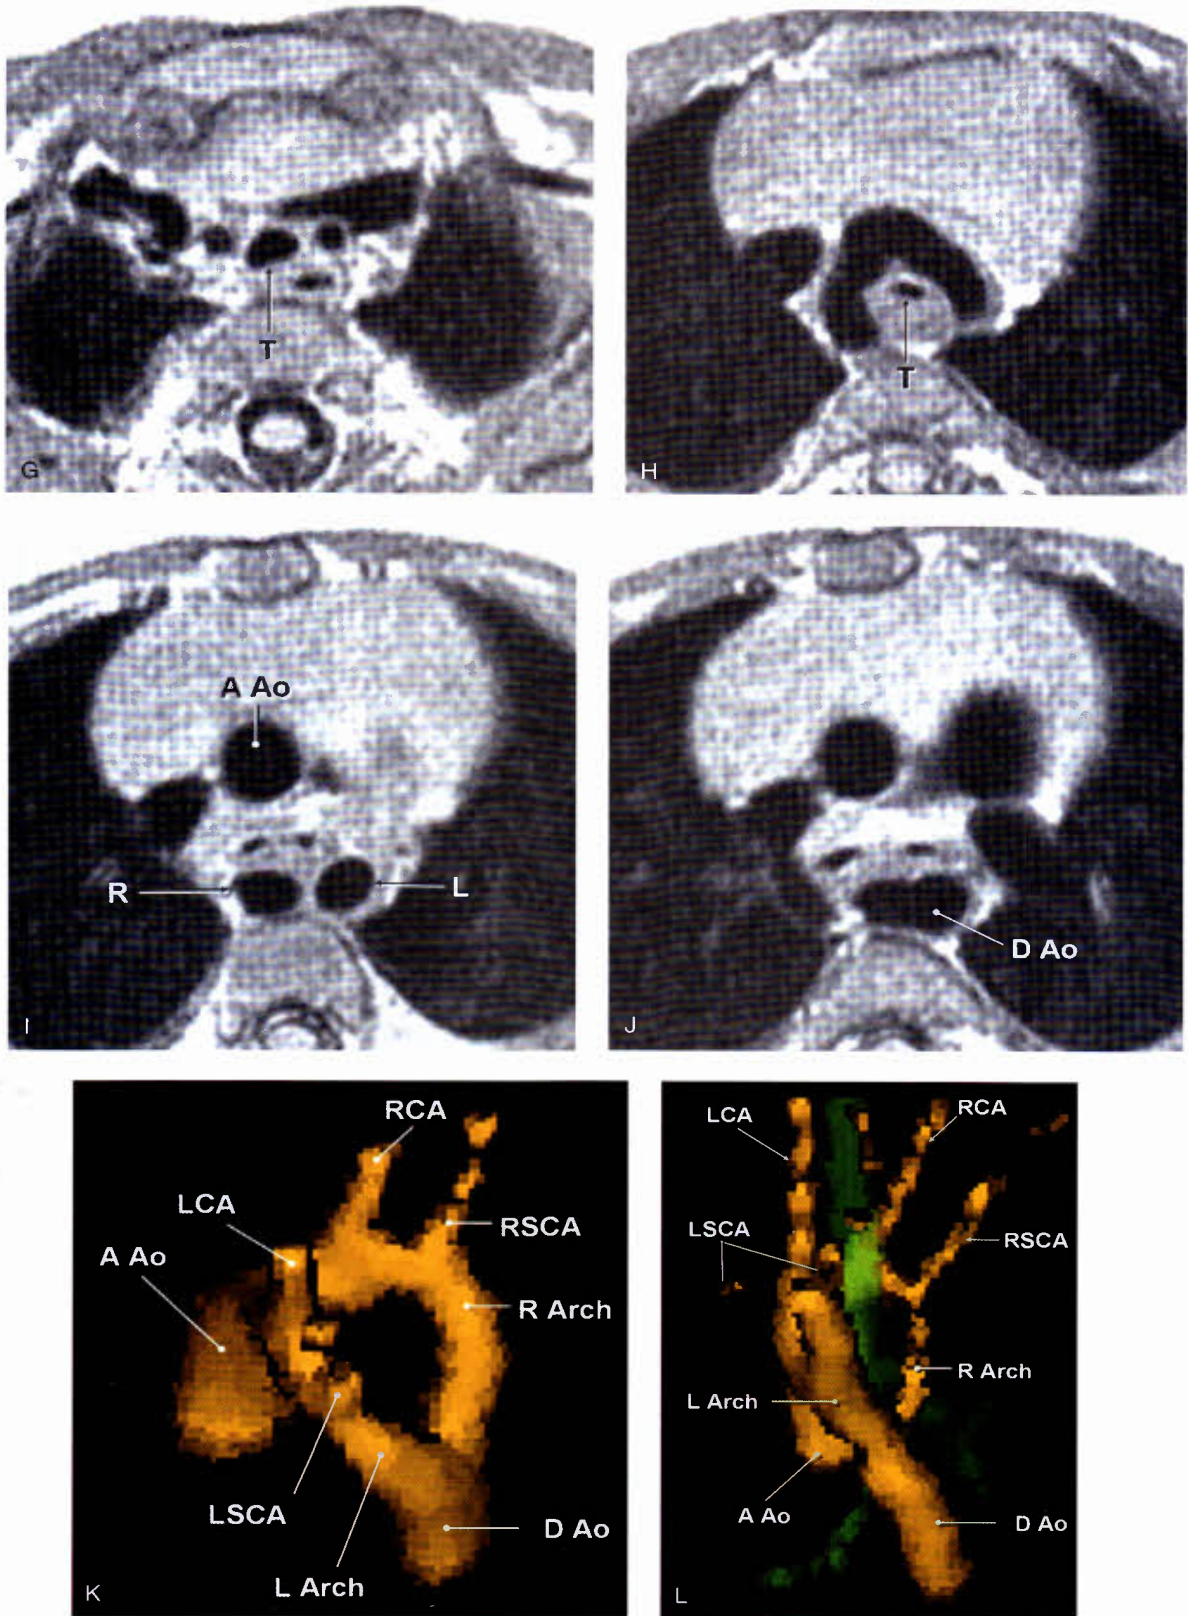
(Continued) G–J: transverse cuts, cranial to caudal, from same patient as (A–D). Note marked decrease in caliber of trachea (T) from (G–H), indicative of tracheal compression. K: Left posterior oblique with cranial angulation view of 3-D shaded surface display from MRI in same patient as (A–D) and (G–J). Note double aortic arch with nearly equal-sized right (R arch) and left (L arch) distal aortic arch components. L: Similar view of patient with rare dominant left arch.
